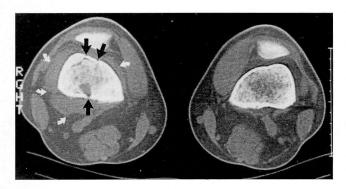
Non-enhanced CT scan of the knees reveals a lytic lesion of the right distal femur with cortical disruption (black arrows) surrounded by a soft tissue mass (white arrows).
